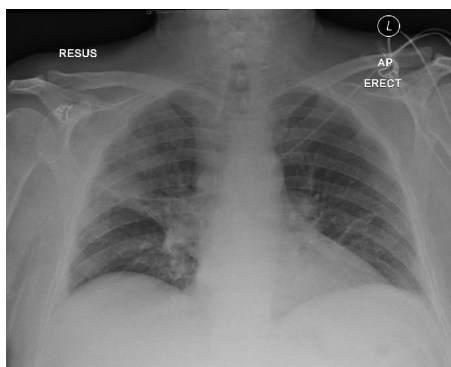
Admission chest radiography showing extensive right mid zone consolidation.
